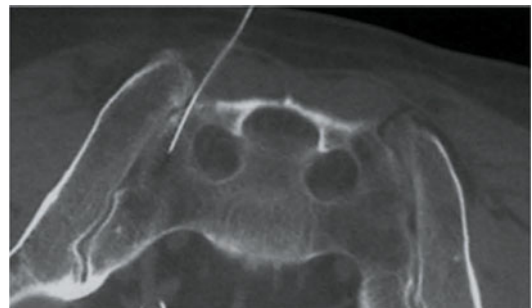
Usefulness of CT guidance when undertaking sacro-iliac injections. The complex anatomy of a sacroiliac joint; nevertheless, the needle is placed correctly within the articular space (a). Changing the width and level of the window can simultaneously allow positioning of the needle with respect to bone (b) and soft tissues (c)
